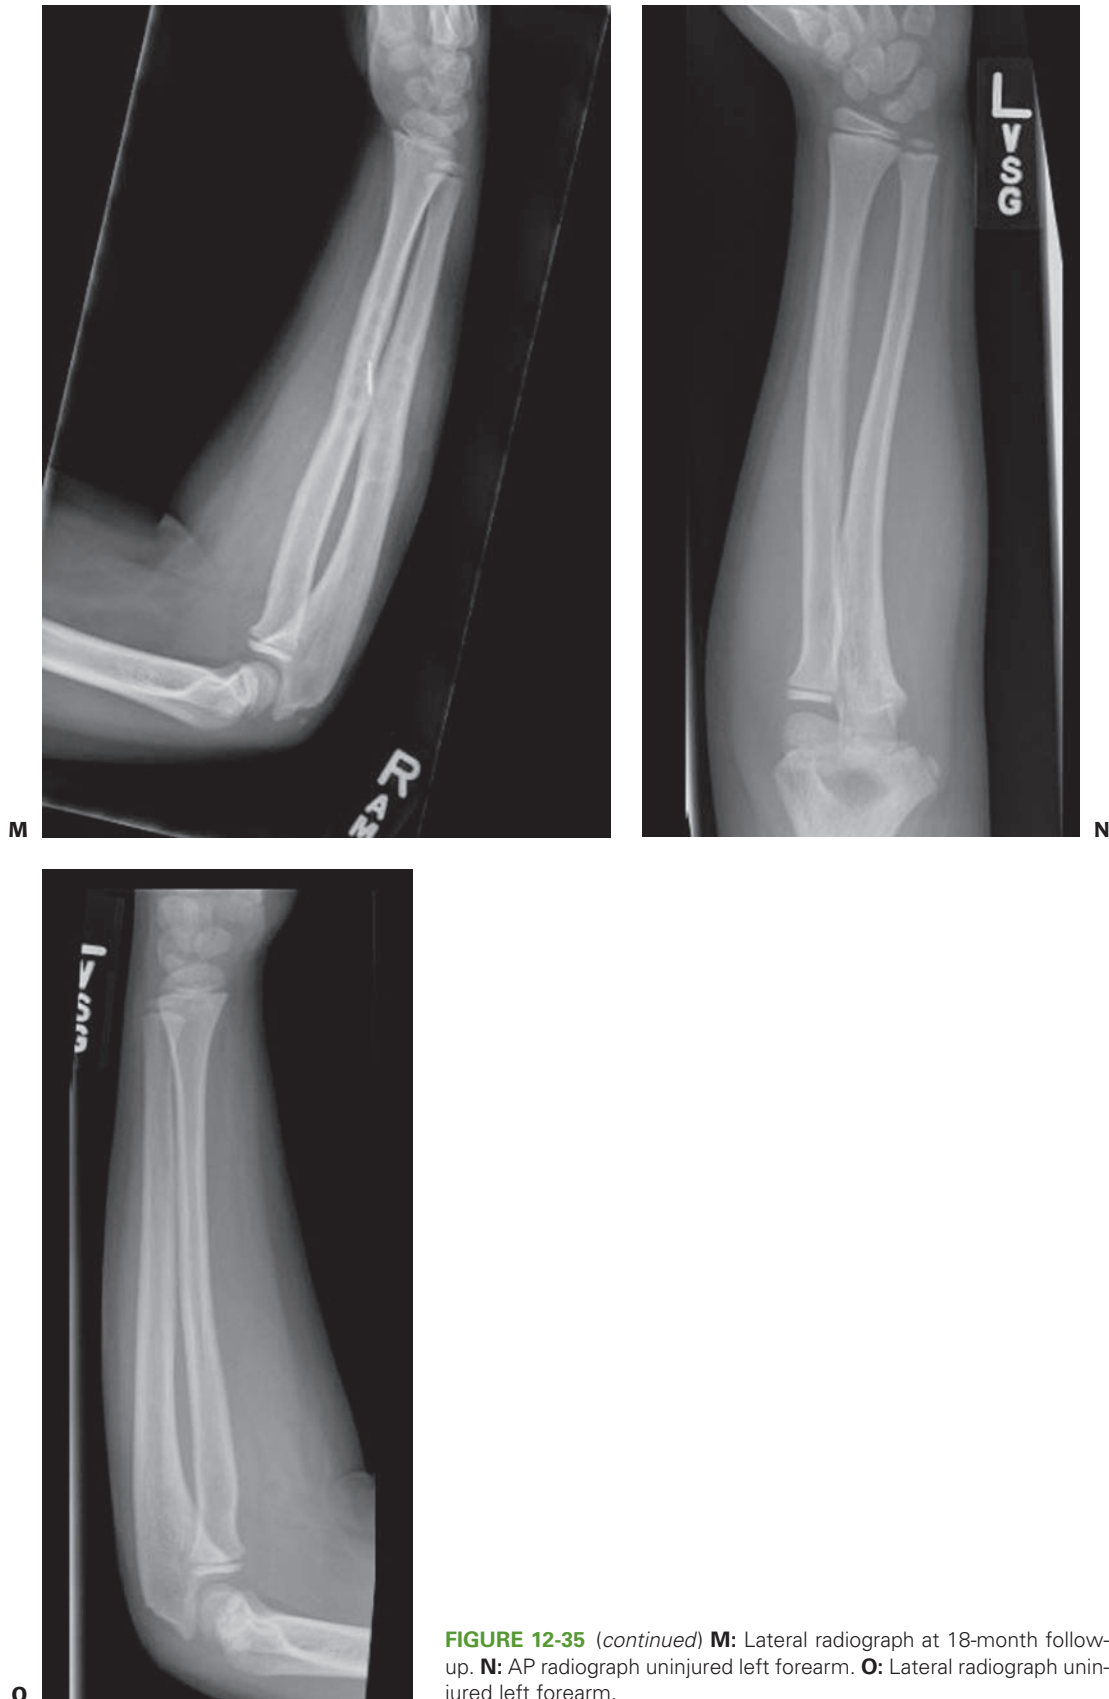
(continued) M: Lateral radiograph at 18-month follow-up. N: AP radiograph uninjured left forearm. O: Lateral radiograph uninjured left forearm.
